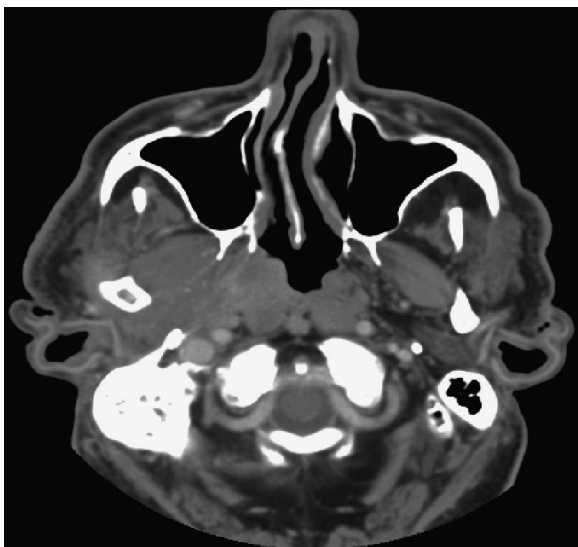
Axial computed tomographic scan shows mild enhancement of the right side of the nasopharynx and right parapharyngeal space with partial involvement of the masticator space.
